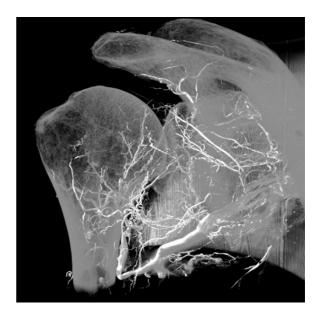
Micro CT scan from the anterior view, showing the blood supply within the humeral head
